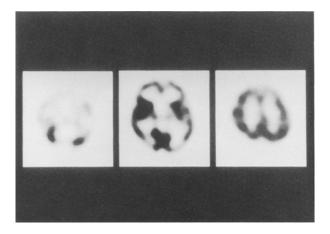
Tc-99m ECD-SPECT on postoperative day 23 shows a decrease of cerebral blood flow (CBF) mainly in the bilateral thalamus, bilateral medial frontal lobes (mainly on the left) and left temporal lobe, as well as reduced CBF in the vermis and bilateral cerebellar hemispheres, indicating the existence of bilateral crossed cerebello-cerebral diaschisis.
